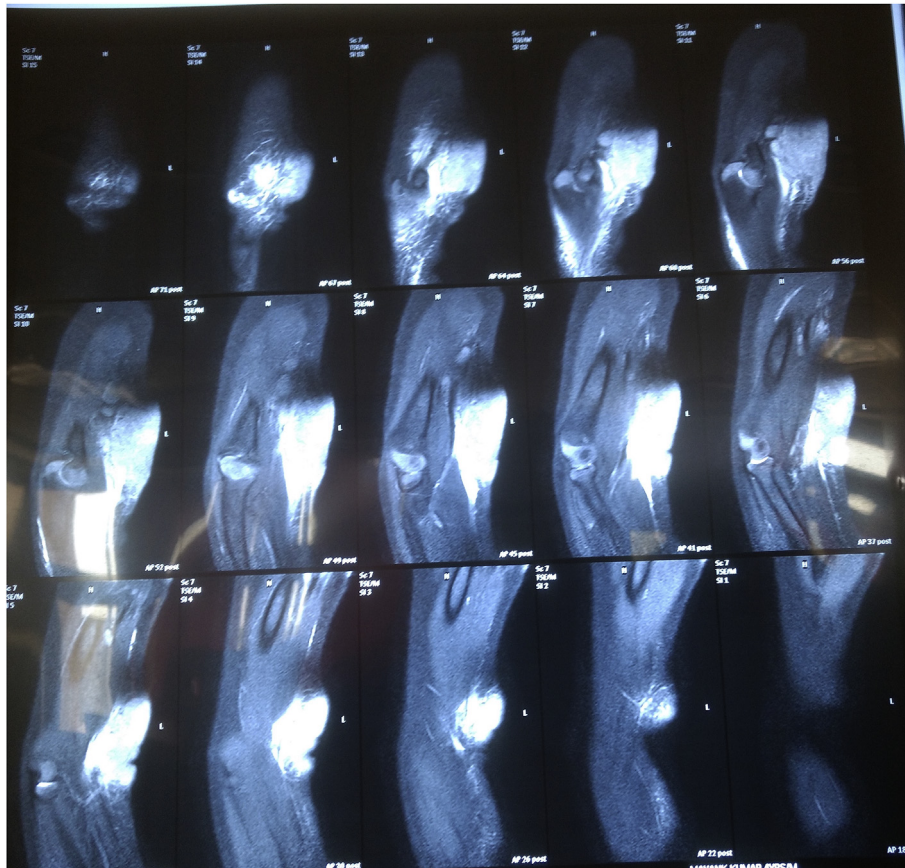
Contrast enhanced MRI of the right distal arm.
